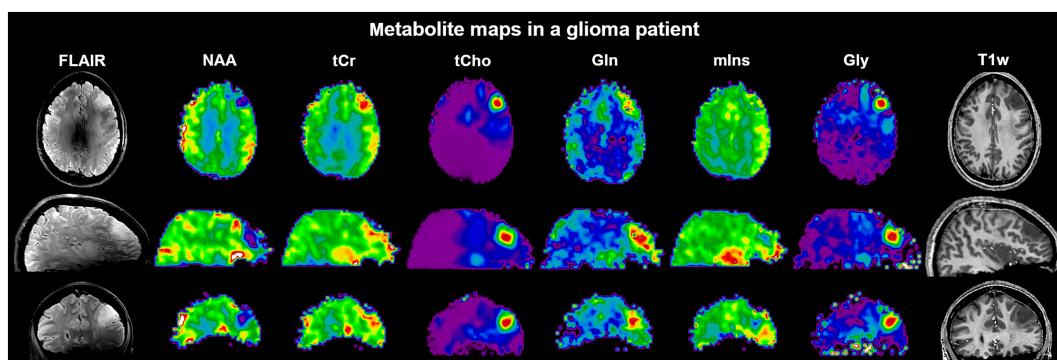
Sample maps of six major metabolites obtained in a brain tumor patient (30-year-old female; anaplastic astrocytoma grade 3 with suspected progression into glioblastoma) along with conventional T_1 - and T_2 -weighted MRI displayed in transversal, sagittal and coronal planes. Whole-brain FID-MRSI data were acquired at 7 T in 15 min using a 3D CRT sequence with variable temporal interleaves, T_R 450 ms, acquisition delay 1.3 ms, spatial resolution $3.4 \times 3.4 \times 3.4 \text{ mm}^3$, $64 \times 64 \times 39$ matrix and SBW 2778 Hz. The T_2 -weighted FLAIR image is strongly affected by B_1 inhomogeneities, while this is less of a problem for gradient-echo-based images such as the T_1 -weighted MRI and metabolic maps. Courtesy of Gilbert Hangel
